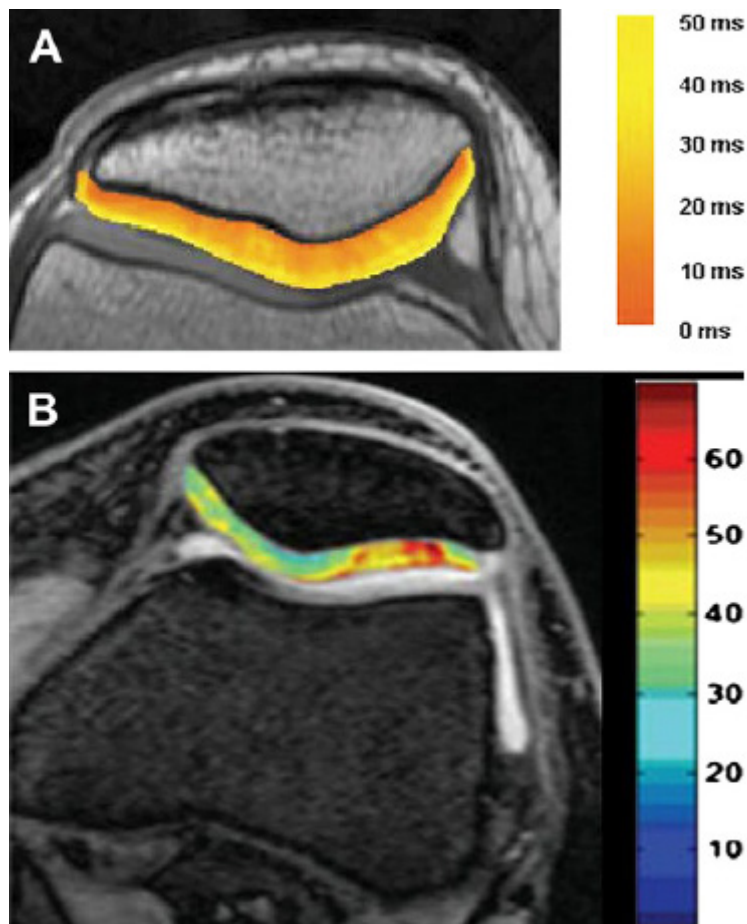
(A) T2 map of patellar cartilage shows variation with cartilage depth. (From Maier CF, Tan SG, Hariharan H, et al. T2 quantitation of articular cartilage at 1.5 T. *J Magn Reson Imaging* 2003;17:363; with permission.) (B) T1 rho map of patellar cartilage demonstrates a lesion in cartilage that is morphologically thick and intact. (From Borthakur A, Mellon E, Niyogi S, et al. Sodium and T1 rho MRI for molecular and diagnostic imaging of articular cartilage. *NMR Biomed* 2006;19:799; with permission.) The variation and lesions apparent in maps of these parameters across morphologically intact cartilage enable monitoring of biochemical changes in cartilage before morphologic changes become apparent.
